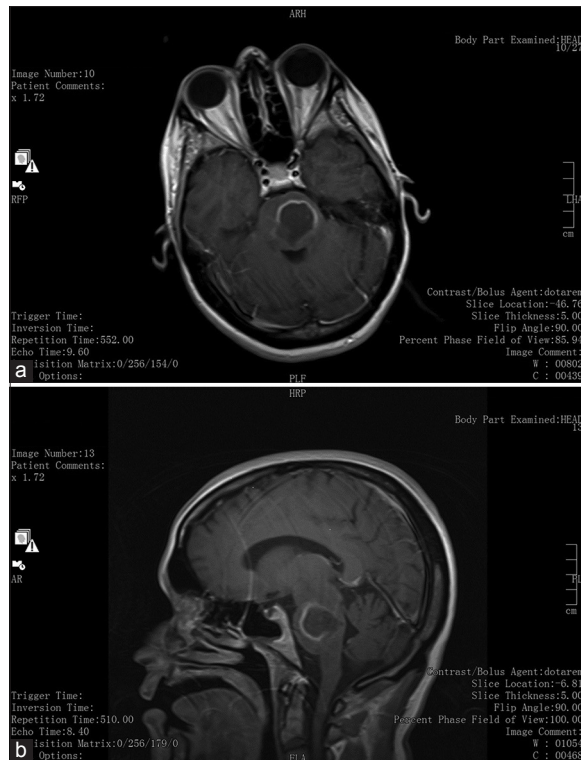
Preoperative magnetic resonance imaging showing contrast (gadolinium) enhancing ring-like lesion in the brain stem (pons) in axial (a) and sagittal (b) orientation
